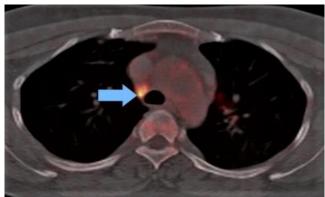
Control PETCT image of the right paratracheal lymph node with spontaneous regression in SUVmax value and dimensions (SUVmax: 7.6)
